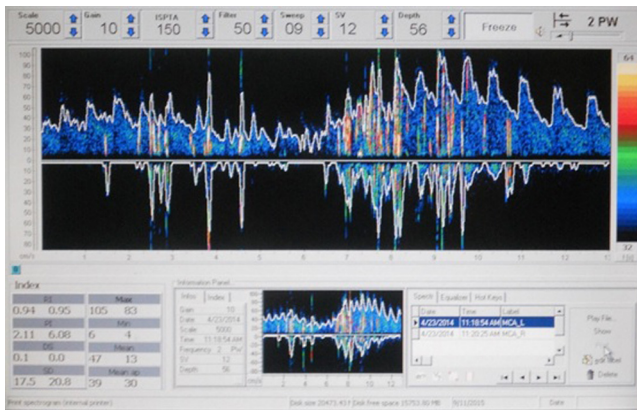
Contrast-enhanced transcranial Doppler demonstrating numerous high intensity transient signals (HITS) during Valsalva maneuver.
